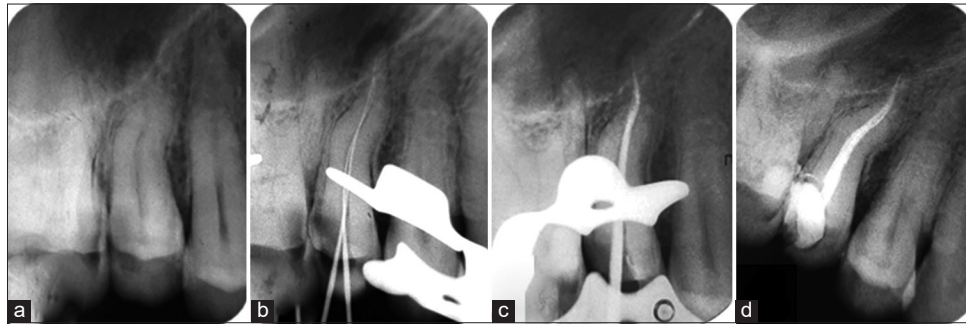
Endodontic management of permanent right maxillary premolar (Tooth #15). (a) Pre-operative radiograph, (b) WL radiograph, (c) master cone radiograph, and (d) post-obturation radiograph
